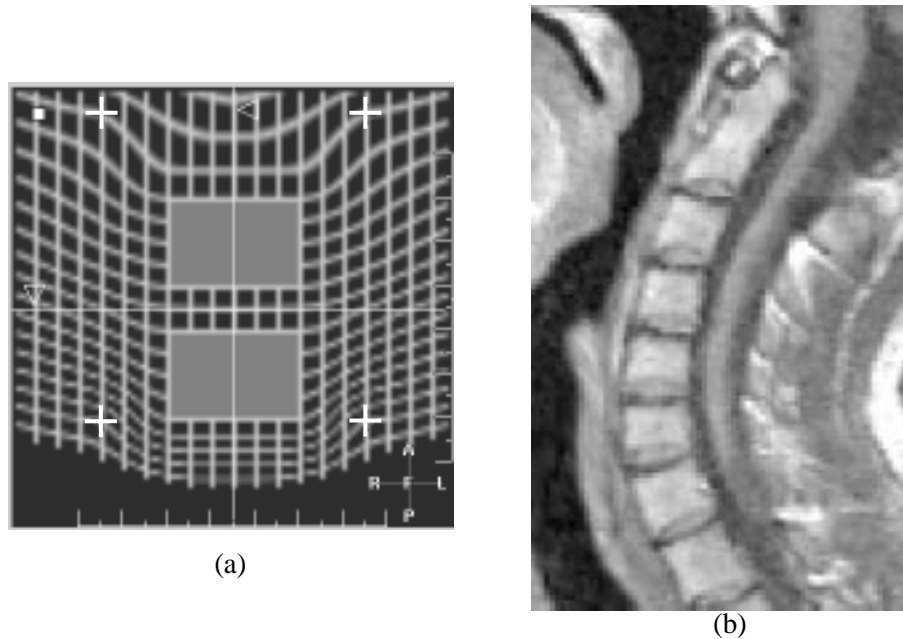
Deformation results using the improved algorithm. Results from deforming the image of a grid with two rigid bodies is shown in (a). Note that deformations close to the rigid bodies are now much smaller. Results from deforming the MR image of the volunteer is shown in (b). Note that the intervertebral discs are now much clearer, compared to figure 8.2(c).
